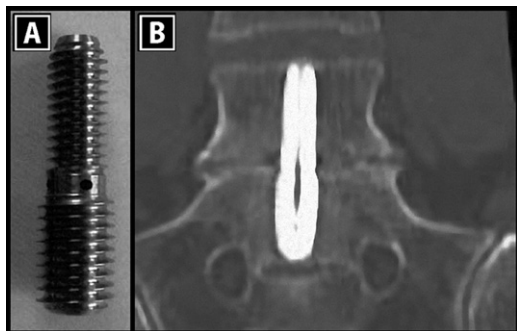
AxialLIF rod device with differential thread pitch to provide interspace distraction during implantation (A). Radiographic image of rod implanted properly in L5-S1 disc space (B).
